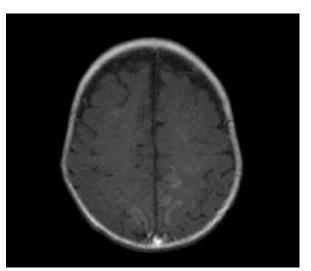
SE/T1 weighted MR images after enhancement – in frontal cortex hyperintense signals (more visible after contrast enhancement) suggestive of passive hyperaemia of the cortex.
